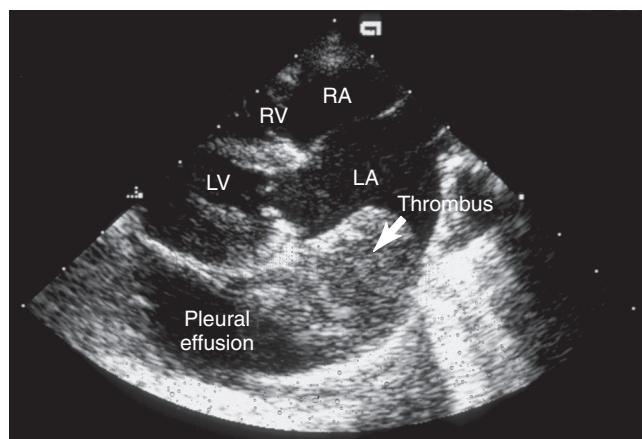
Right-parasternal long-axis echocardiographic image demonstrating a large left atrial thrombus. A pleural effusion can be observed distal to the heart on the image.
